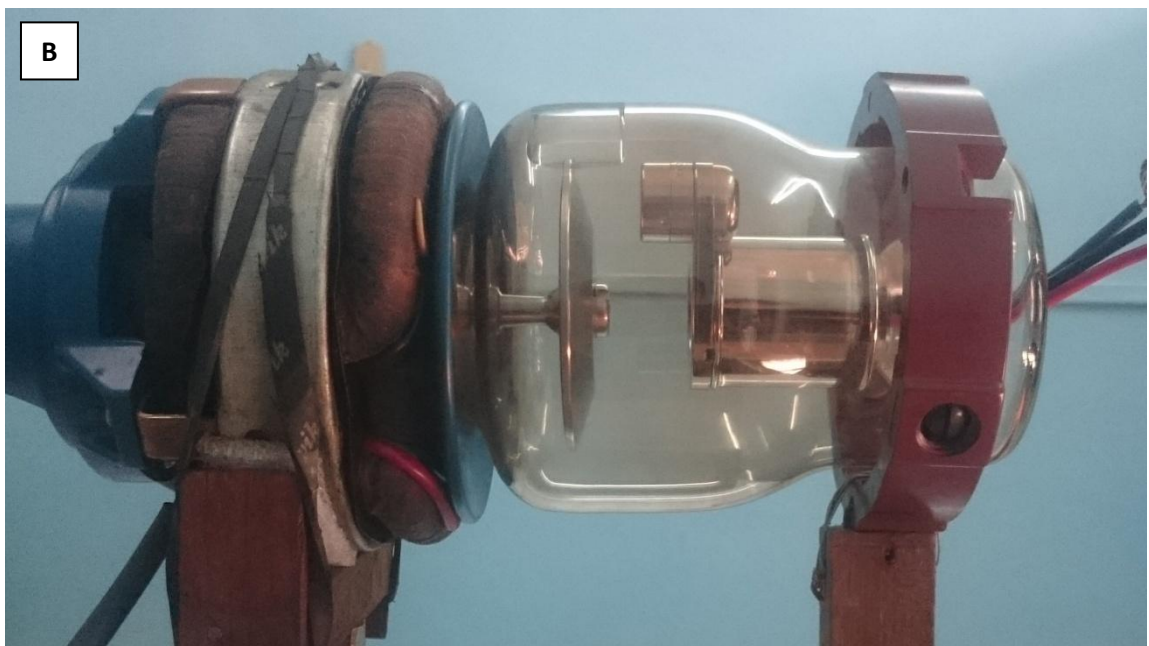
(b): Realistic picture of conventional X-ray tube
